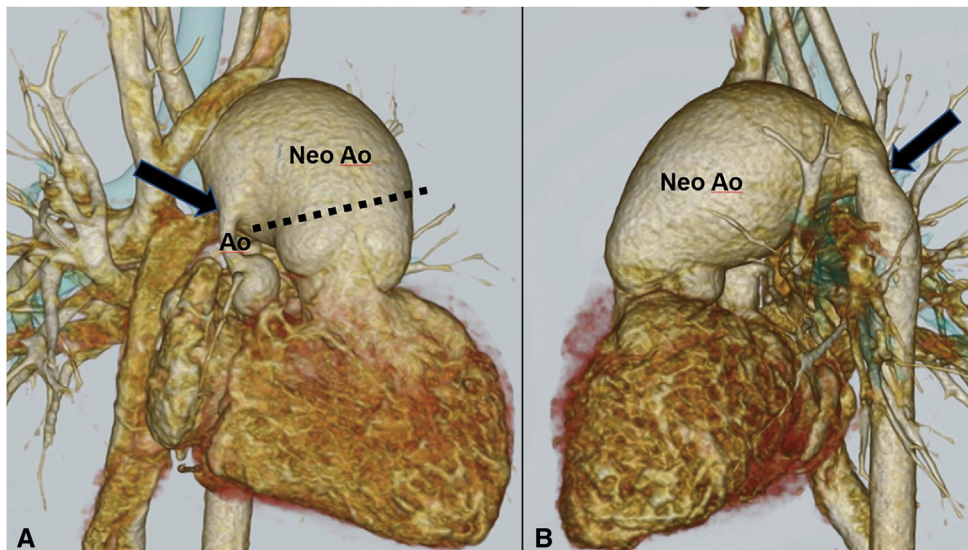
Preoperative computed tomography image. A, Anterior view showing marked dilation of the neoaorta. The *black arrow* shows connection site between original aorta and neoaorta. The *dashed line* shows the neo-aortic clamp site. B, *Left lateral view* showing coarctation of aorta (*black arrow*). *Ao*, Original aorta; *Neo Ao*, neoaorta.
